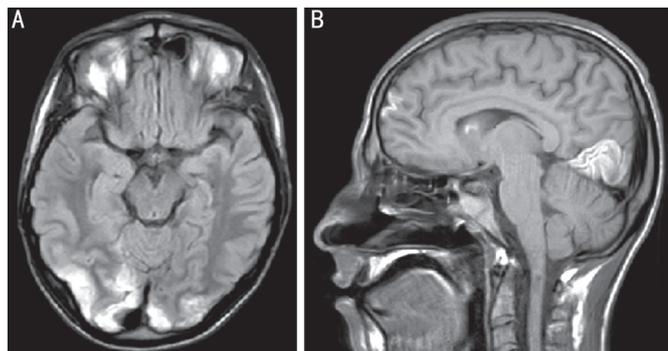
MRI scan of a 21-year-old male patient suffering from advanced pulmonary CF showing ischemic injuries of subacute chronology with hypotensive origin pattern.
